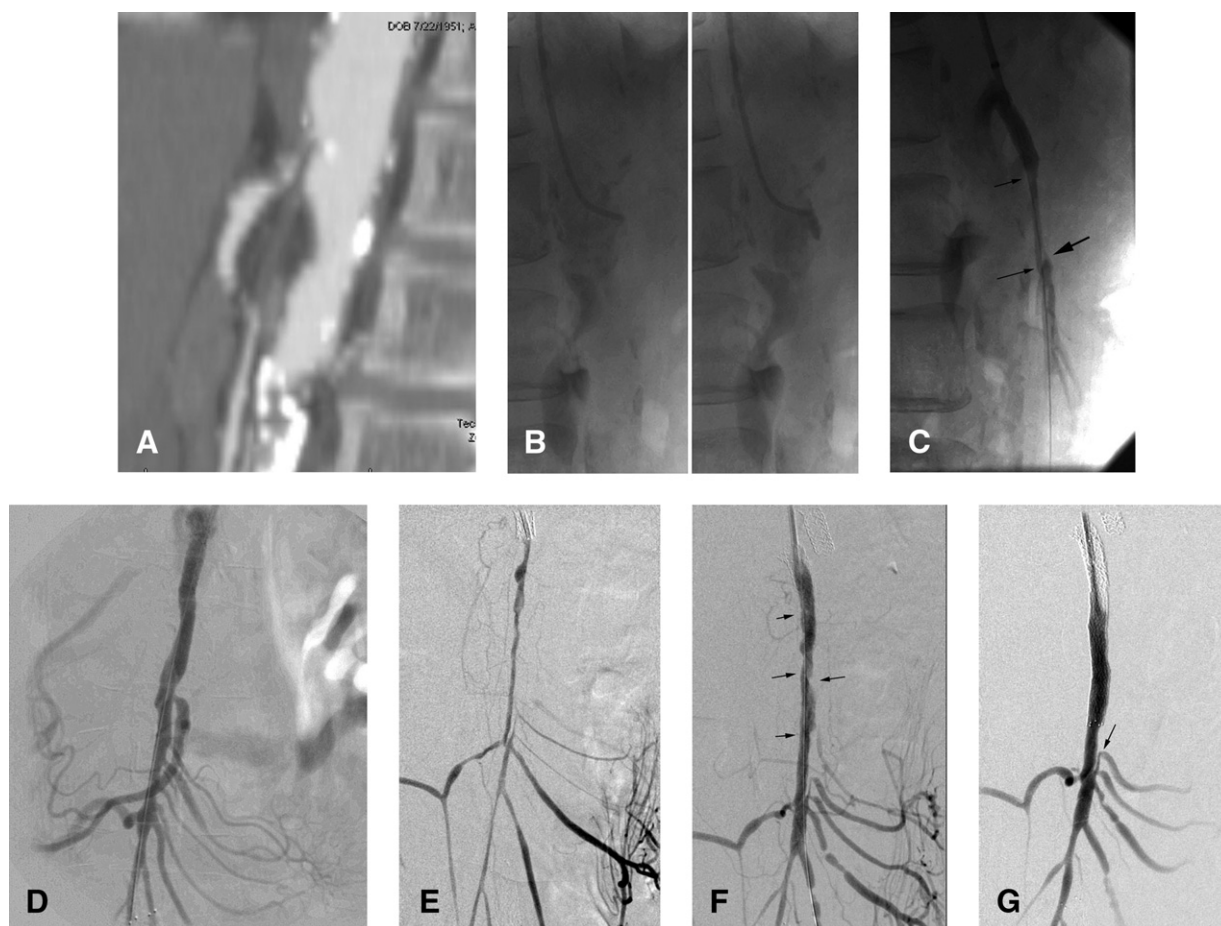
Sixty-year-old woman with extensive peripheral vascular disease presenting with severe postprandial pain, fear of eating, and 20-pound weight loss. A, Lateral reconstruction of a contrast-enhanced computerized tomography (CT) of the abdomen shows a 3-cm-long occlusion of the superior mesenteric artery (SMA) with no visible stump. B, Progressive burrowing at the suspected level of the obliterated SMA stump, using the celiac artery and visible calcifications on fluoroscopy as a reference. C, Ostial stenting of the SMA with balloon dilatation of the recanalized track shows recoil of the subintimal track. D, Final appearance following prolonged inflation of 5-mm balloon diameter shows an optimal anatomic result. E, Angiography showed in-stent restenosis and restenosis/recoil of the subintimal-true lumen fenestration. F, Following scoring balloon angioplasty, there is improved flow but hazy appearance of the mid-SMA. G, Final result following placement of a 6- × 100-mm self-expanding nitinol stent.
